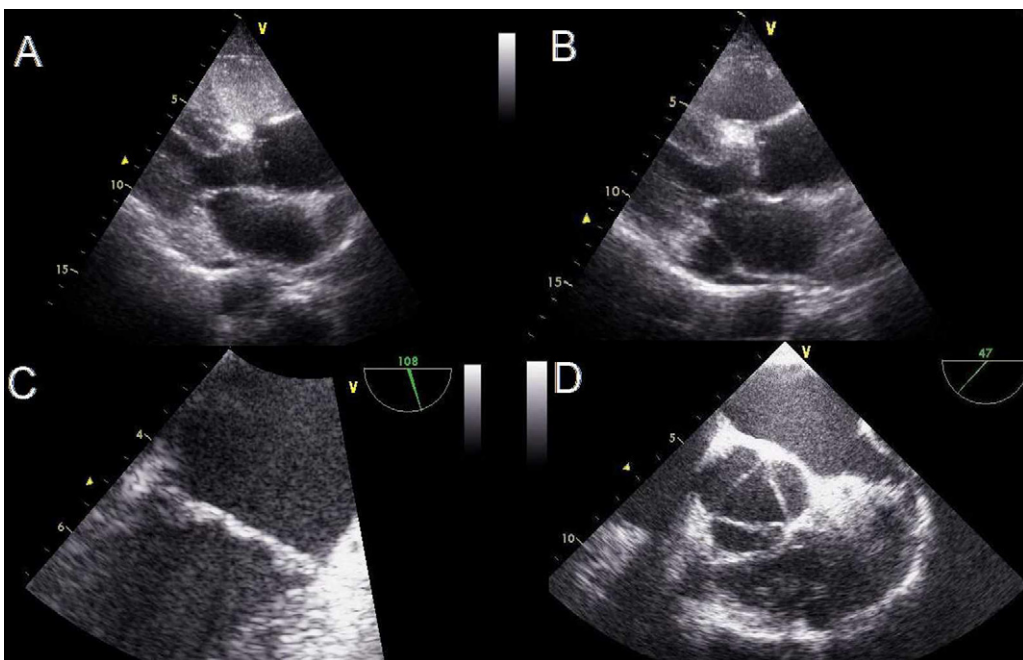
(A and B) Transthoracic echocardiographic images of the patient. Interventricular septum thickness was 1.3 cm and posterior wall thickness was 1.2 cm. (C and D) Transesophageal echocardiographic images of the patient. There were no visible vegetations on mitral (C) and aortic (D) valves.
